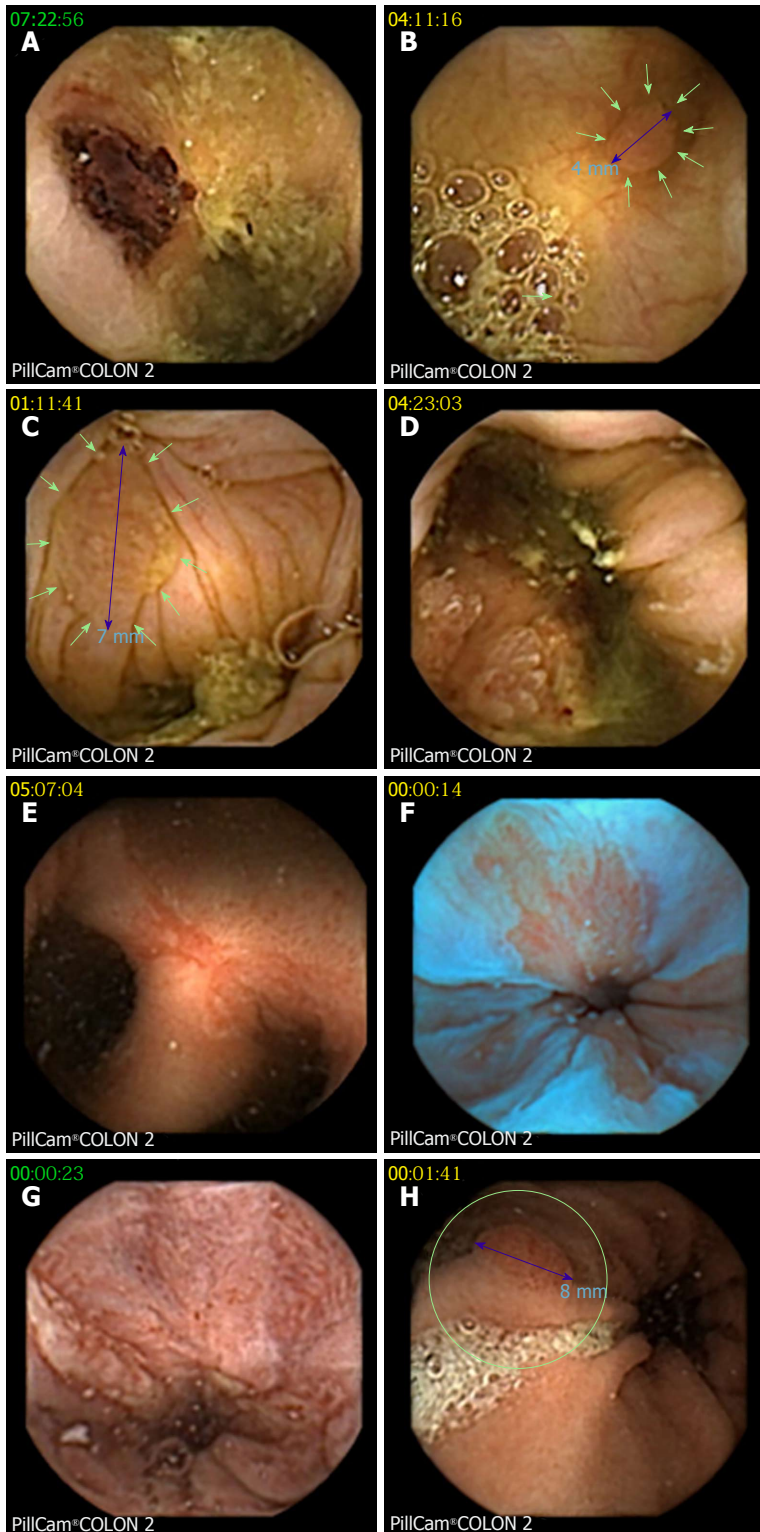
Examples of findings at colon capsule endoscopy. A: Biopsy tattoo after optical colonoscopy; B: One of three 4 mm polyps in the ascending colon, confirmed at consecutive balloon enteroscopy as tubular adenoma; C: Significant (7 mm) polyp; D: Cecal adenocarcinoma (confirmed by surgery); E: Fistulating and stenosing Crohn's disease of the ileum (confirmed by enteroclysis, CT scan, and surgery); F: Irregular Z-line suggestive of Barrett's esophagus (blue mode image); G: Reflux esophagitis; H: Gastric polyp (consecutive gastroscopy found foveolar hyperplasia and autoimmune gastritis with vitamin B12 deficiency).
